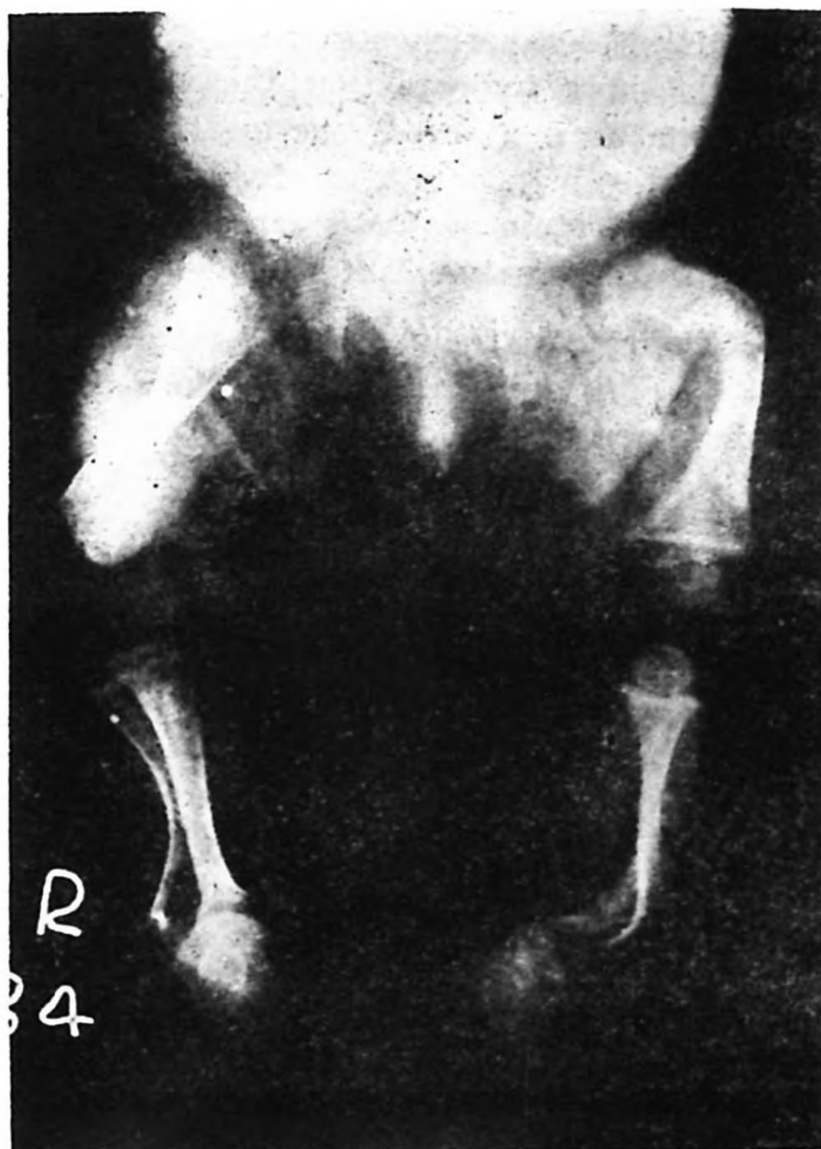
X-ray of lower extremities after five months of treatment.
